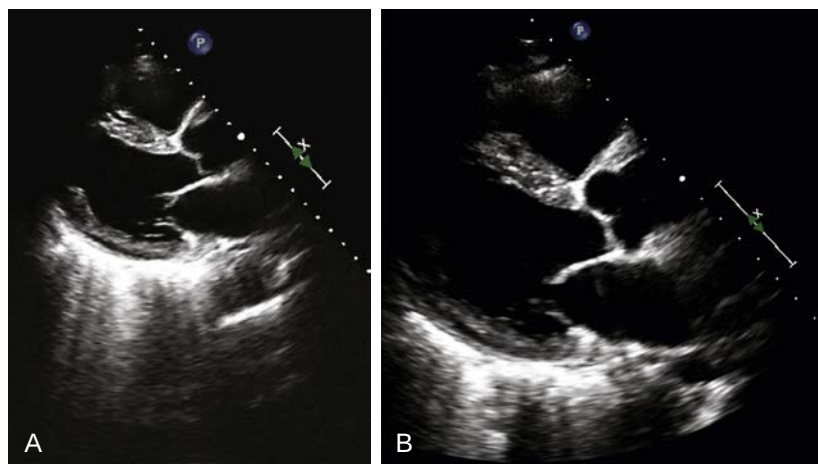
Parasternal long-axis view. (A) Initially images are recorded at a depth of 18 cm to show the structures posterior to the heart (*top*). (B) Next, images are recorded with the depth decreased to 13 cm and the resolution mode used (note that the top of the displayed image now is 2 cm from the skin) to focus on the aortic and mitral valves.
